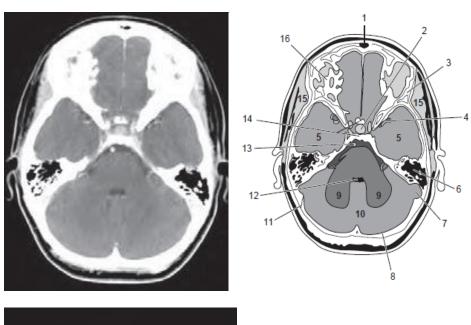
Cross Sectional Anatomy of CT Brain at the level of medulla¹⁰.
